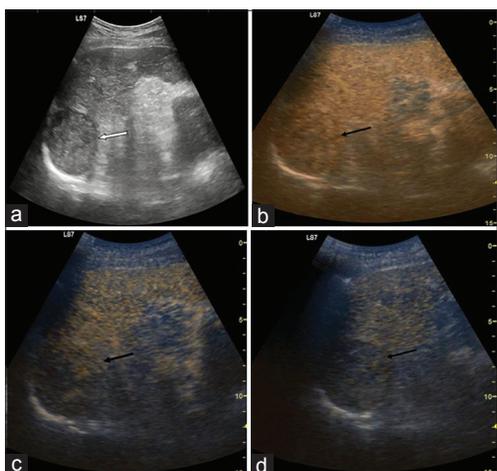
A 64-year-old male patient; case of chronic parenchymal liver disease. On follow-up conventional ultrasound (white arrow a), the patient is found to have space-occupying lesion and portal vein thrombosis. Serum alpha feto protein (AFP) level is 9727 ng/ml. Contrast-enhanced ultrasound is done targeting the larger lesion in the right lobe of the liver showing enhancement of the lesion in arterial phase at 22 seconds after contrast injection (black arrow, b) and washout in venous phase at 74 seconds (black arrow, c) and complete washout at delayed phase at 175 seconds (black arrow, d). Diagnosis is confirmed as hepatocellular carcinoma by biopsy
